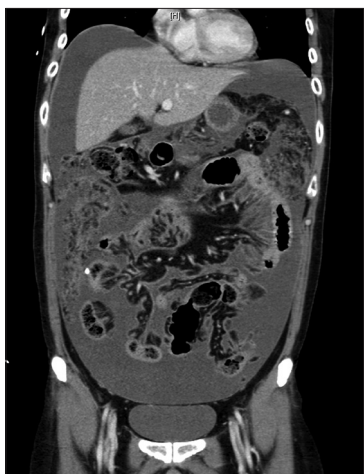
Computed tomography scan of the abdomen showing ascites with diffuse peritoneal enhancement with diffuse omental thickening and stranding
